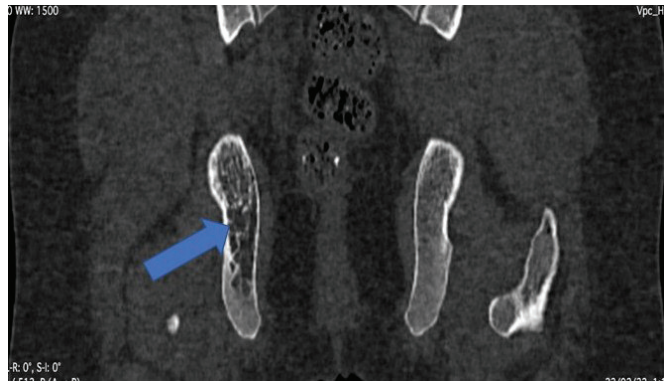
Coronal reformatted CT image showing the extent of the ischial lesion (arrow).
